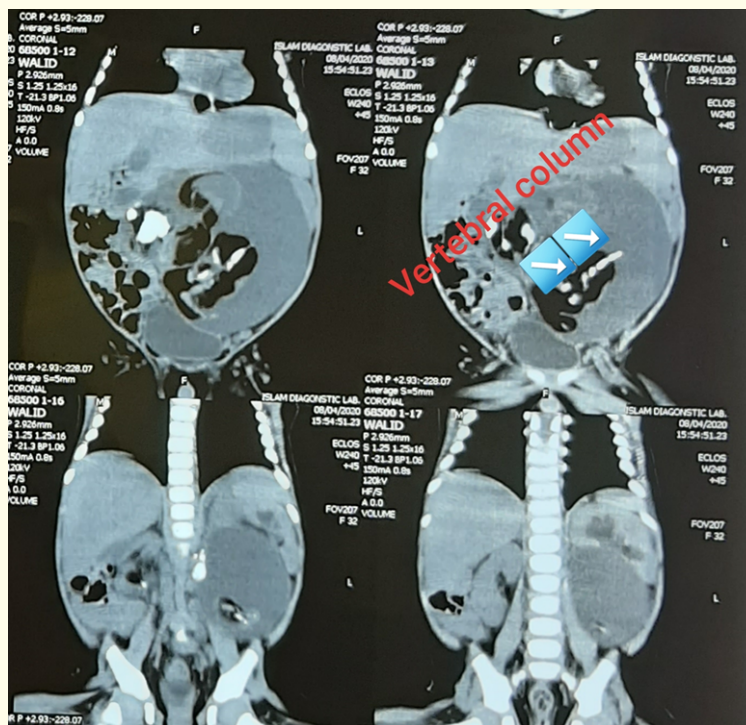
CT scan of Abdomen. Arrow shows vertebral column of FIF.
